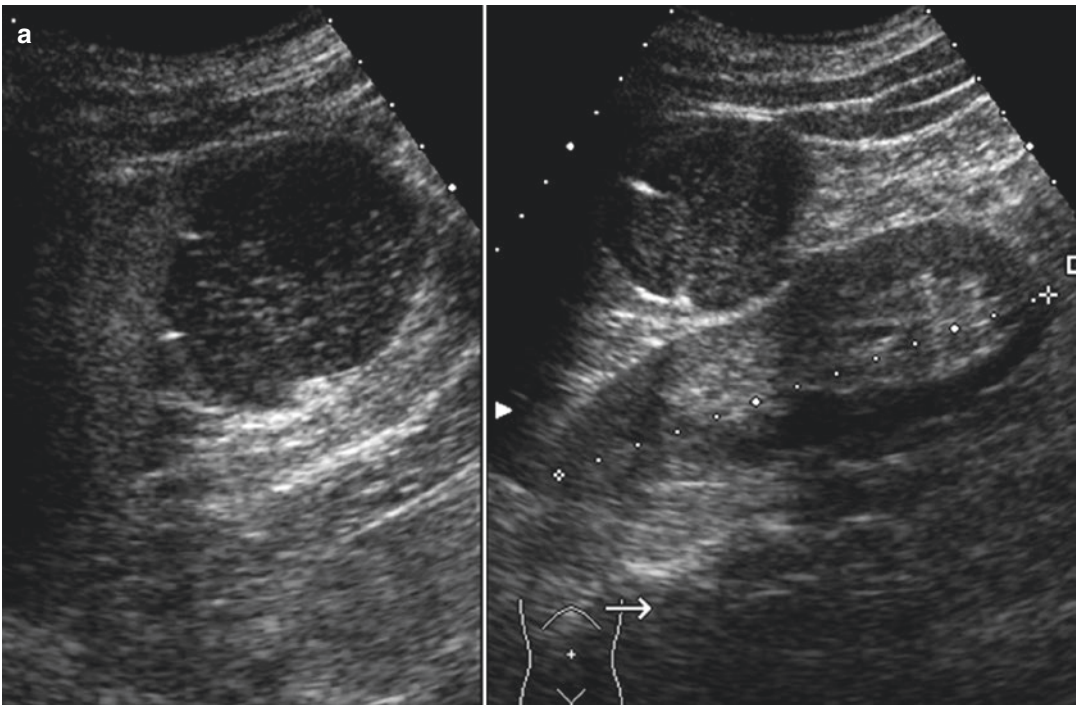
(a) Exophytic cyst with inhomogeneous and corpuscular content in a patient with fever and shaking chills: infected cyst. (b) Partly exophytic cystic formation with endocystic iso-anechoic level: intracystic bleeding with declive layers of echoes. (c) Cyst containing blood. US (multiple low-level echoes) and CT axial view (hyperdense oval lesion without intravenous administration of iodinated contrast medium)
